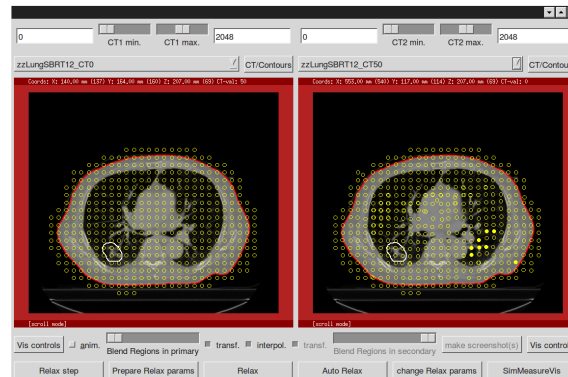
Matcher 3D*: Example of the distribution of subvolumes in an axial plane of the lungs. To the left, the CT0 phase (the maximum inhale CT) is chosen as reference image. The CT50 phase (the maximum exhale CT) image to the right have been assigned subvolumes corresponding to the subvolumes of the reference image. The circles are the centres of the subvolumes, where the filled circles are the ones centred in plane. The white contour depicts the PTV structure.
